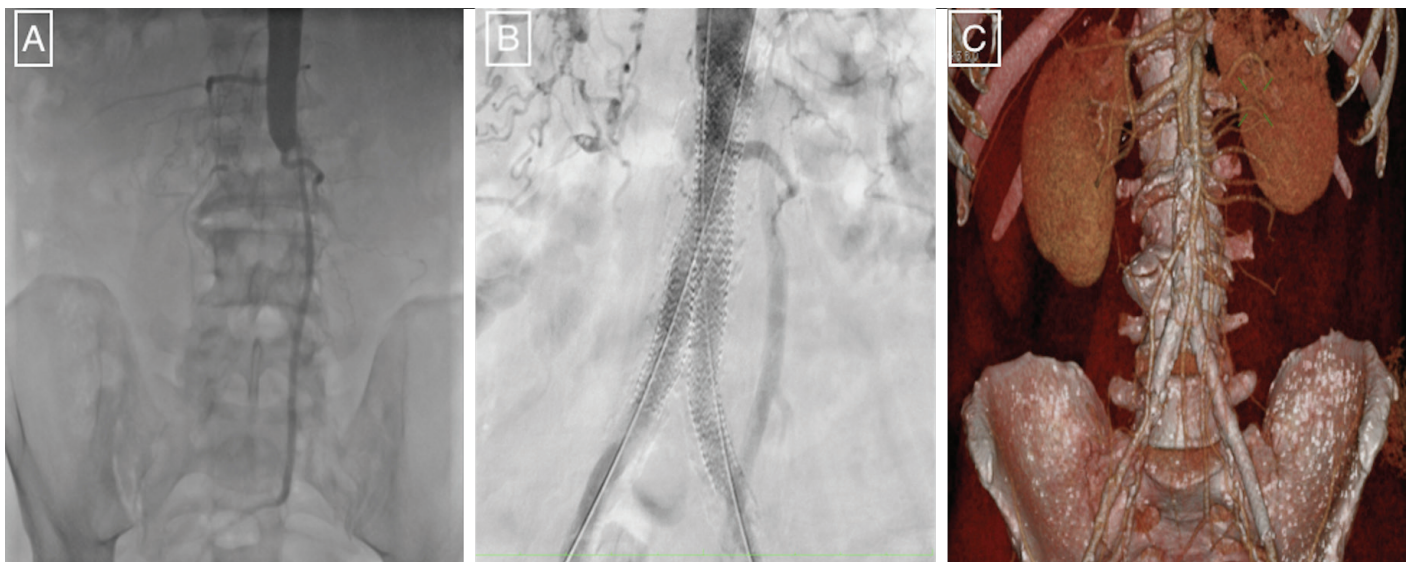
(a) Antegrade aortic occlusion angiography; (b) Completion angiography after aortoiliac kissing stent deployment; (c) 24th month follow up CT scan
